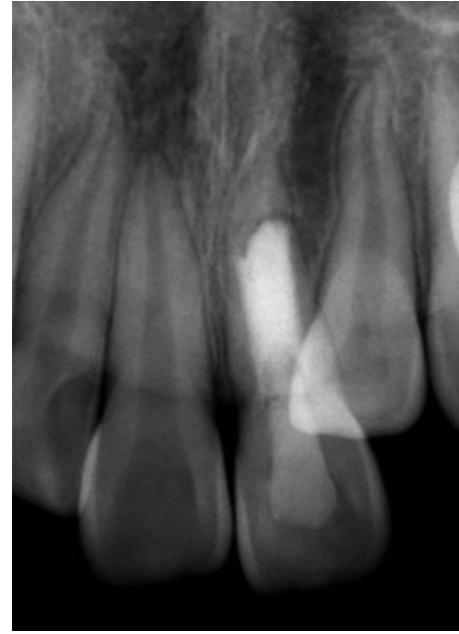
Three-year and six-month follow-up periapical radiograph showing more resolution of radiolucency and apparent hard tissue under mineral trioxide aggregate plug.
